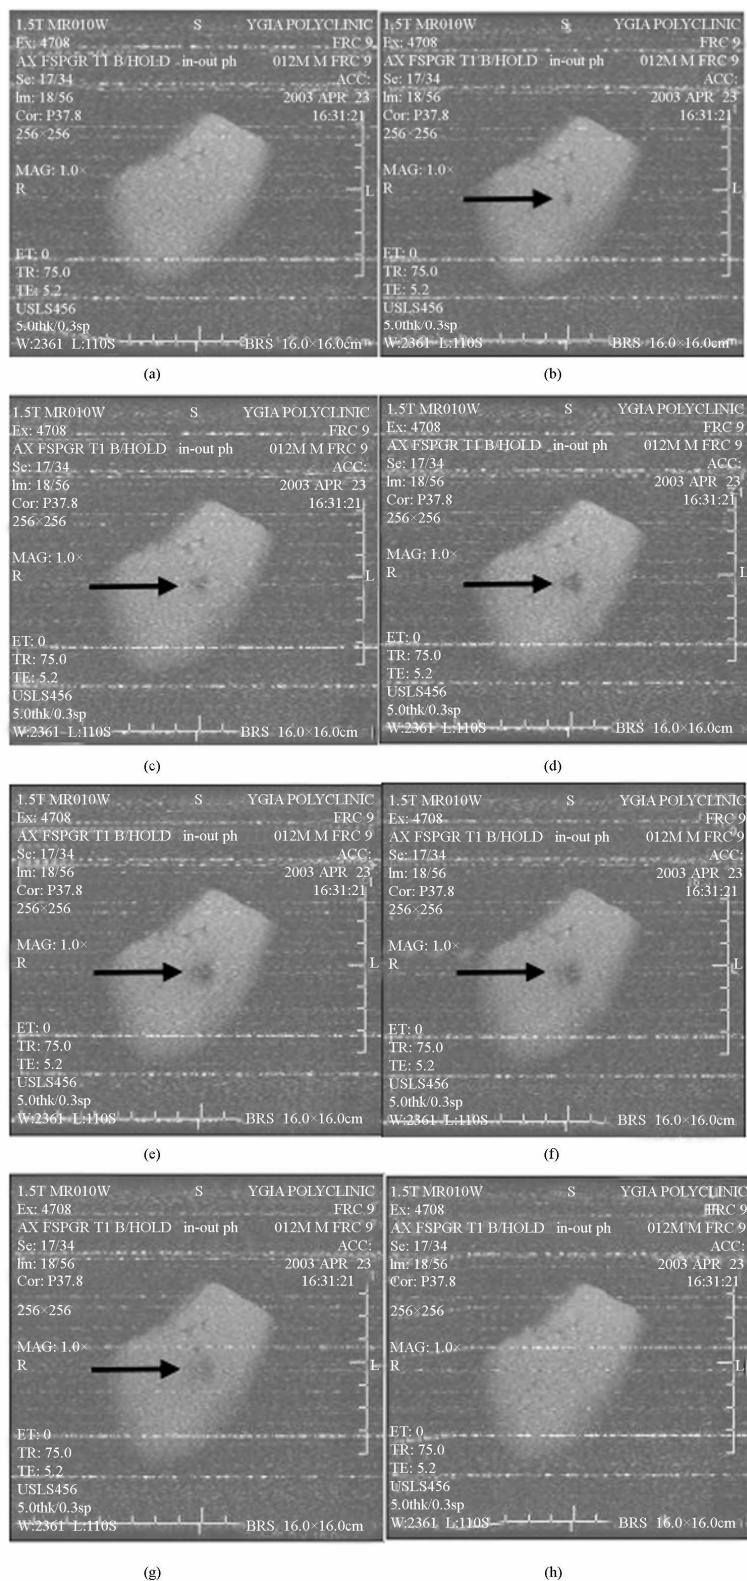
Temperature evolution *in vitro* kidney using T1- weighted FSPGR (thermal mechanism). Each image was acquired in 5 s. (a) Ultrasound is OFF; (b)-(f) Applied spatial average intensity: 1000 W/cm² (for 25 s); (g)-(h) Ultrasound is OFF.
